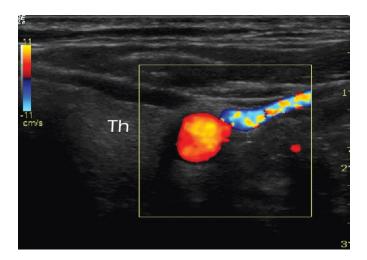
Colour Doppler produces a color-coded map of Doppler shapes superimposed onto a B-mode ultrasound image
